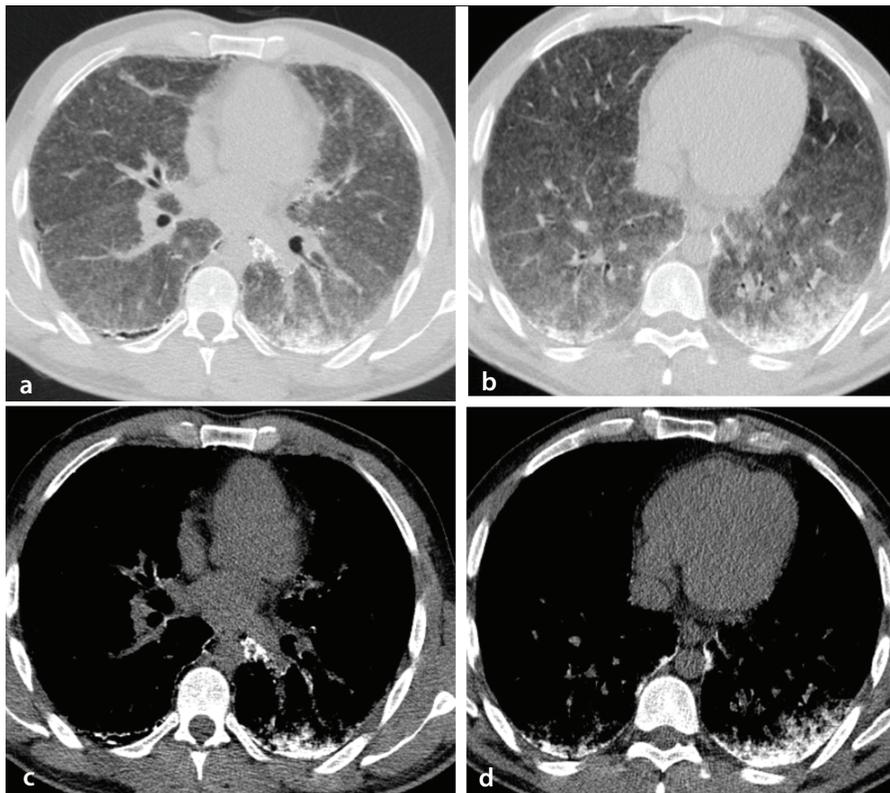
Pulmonary alveolar microlithiasis pattern on chest computed tomography (CT). Axial CT images (a, b) in lung windows show diffuse, sand-like calcific micronodules creating a dense "ground-glass" appearance with subpleural predominance. Corresponding mediastinal window images (c, d) highlight extensive subpleural and parenchymal calcifications.
